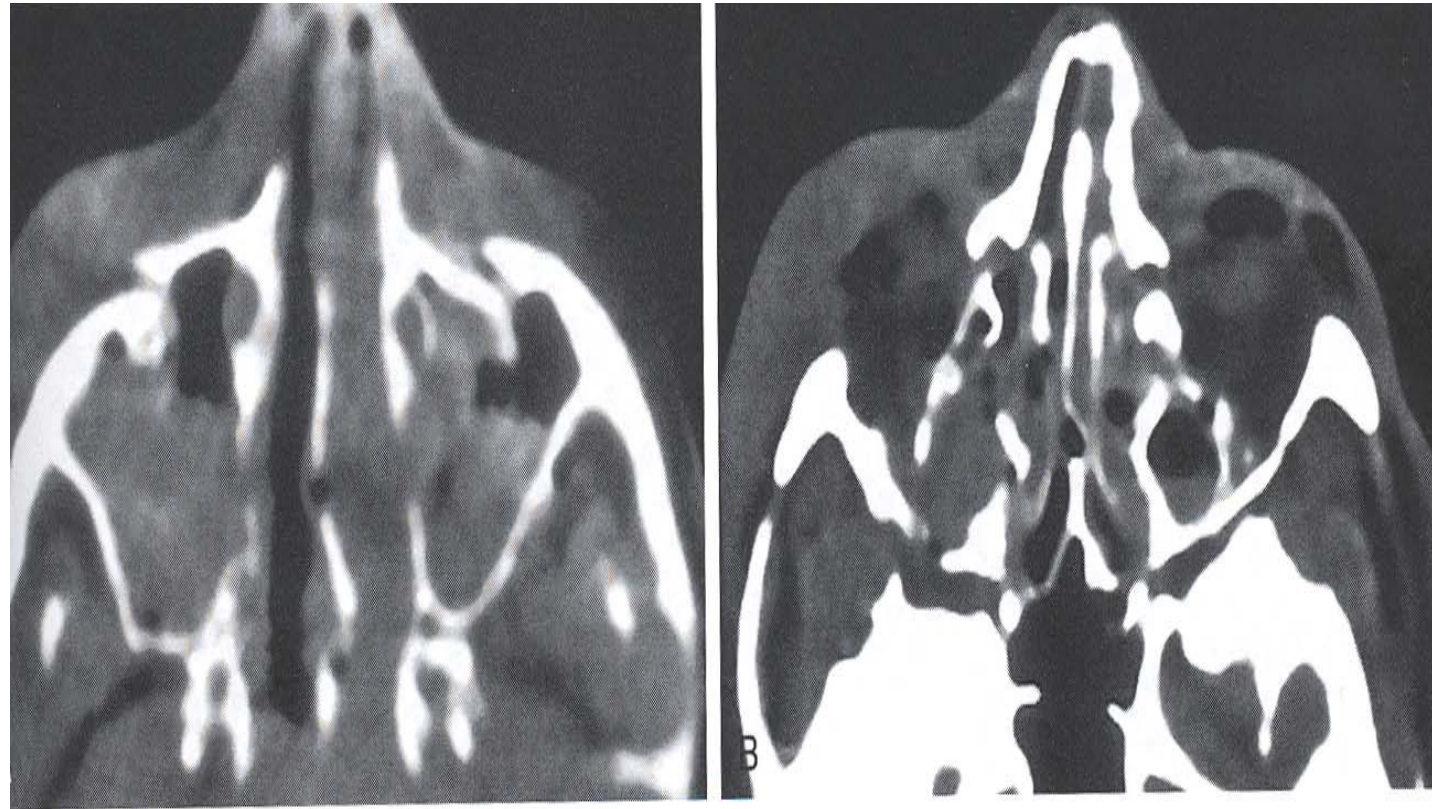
Axial CT scans show a Le Fort III fracture. The more caudal aspects of the fracture (A) are similar to those of a Le Fort II fracture. However, the more cranial fractures (B) separate the facial bones from the cranium.
